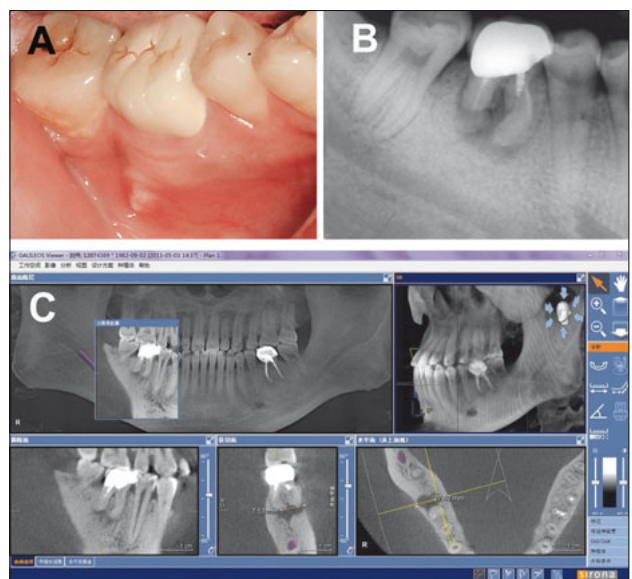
(A) Clinical image of tooth 46. (B) Preoperative periapical radiograph. (C) CBCT images revealed the morphological characteristics of the DL root.
